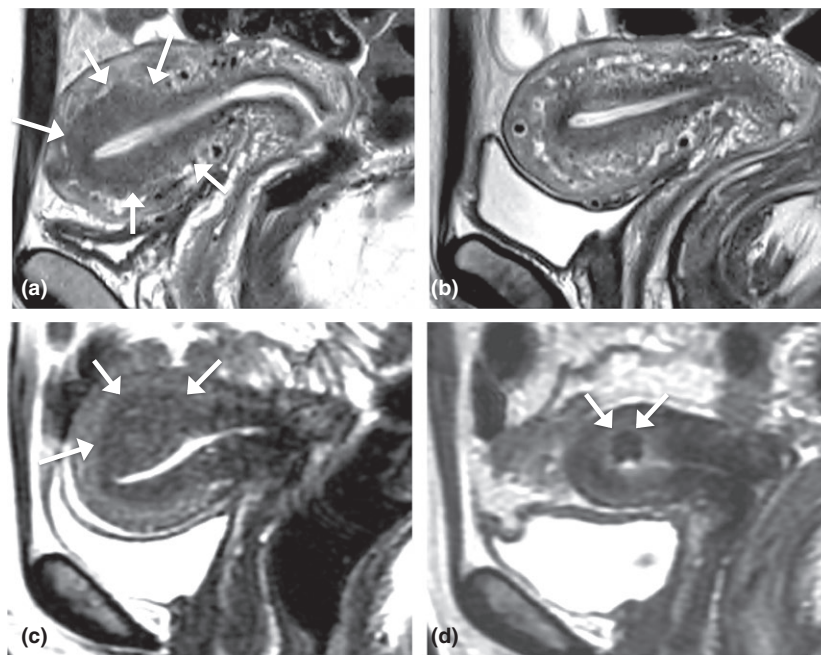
Case 1: Twenty eight year old G3P3 with no desire for future pregnancy, presented with severe HMB. NSAIDs were not effective; tranexamic acid has exacerbated dysmenorrhoea; LNG-IUD (Mirena) was not tolerated due to acne and continuous spotting. MRI pre-embolisation (a) showed thickening of junctional zone in the upper body/fundal region. MRI 6 months post-embolisation (b) showed normalisation of junctional zone. Patient reported lessening of menstrual flow, resolution of dysmenorrhoea and improvement of quality of life. Case 2: Fifty two year old G3P3 with severe HMB and dysmenorrhoea. Pre-embolisation MRI (c) demonstrated focal adenomyosis/adenomyoma; Post-embolisation MRI at 6 months (d) showed low signal focus of infarcted adenomyoma.
